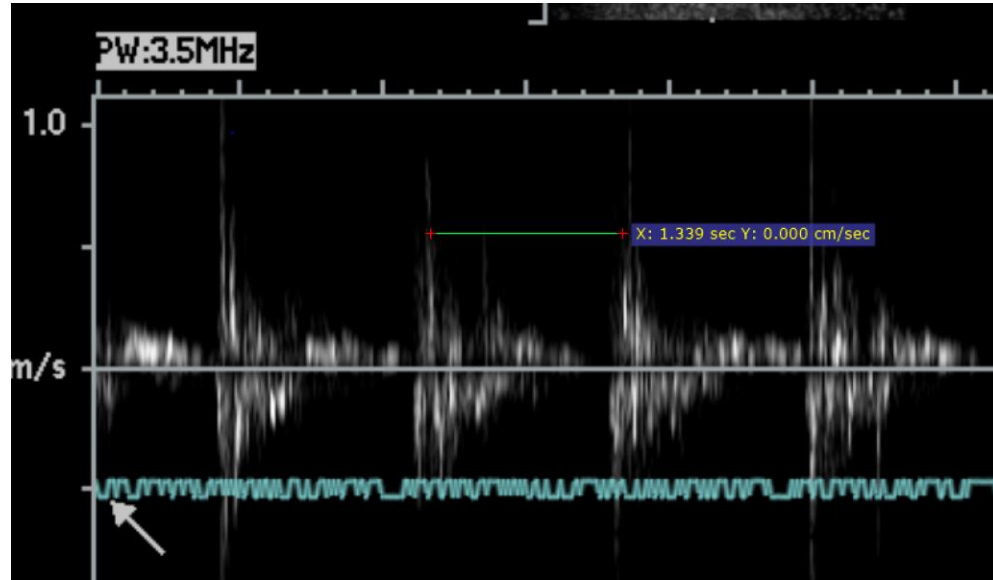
Flow pulse wave measured on the ultrasound machine. The cardiac cycle corresponded to the cycle set on the SmartMotor™ (MOOG Animatics, United States).
